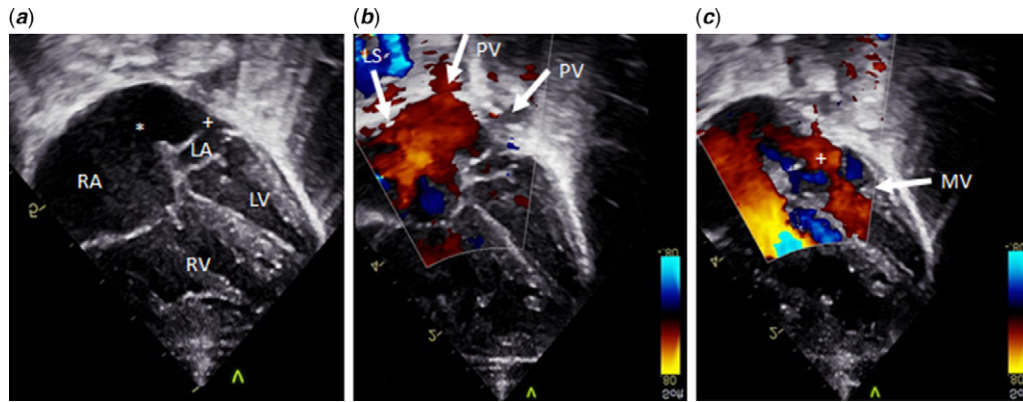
Pre-operative transthoracic echocardiographic findings in our patient, subcostal 4-chamber views. (a) Bidimensional subcostal 4-chamber view showing significant leftward orientation of the primary septum and small left heart structures with a dilated RA and RV; (b) colour subcostal 4-chamber view showing a hypoplastic limbus superior and normal pulmonary venous connection to the left side of the atrial body; (c) colour subcostal 4-chamber view showing an atrial communication between the primary septum and the posterior wall of the LA permitting antegrade blood flow through the mitral valve. * = atrial septum defect; + = fenestrated displaced flap valve of the oval fossa; LA = left atrium; LS = limbus superior; LV = left ventricle; MV = mitral valve; PV = pulmonary vein; PV = pulmonary veins; RA = right atrium; RV = right ventricle.
